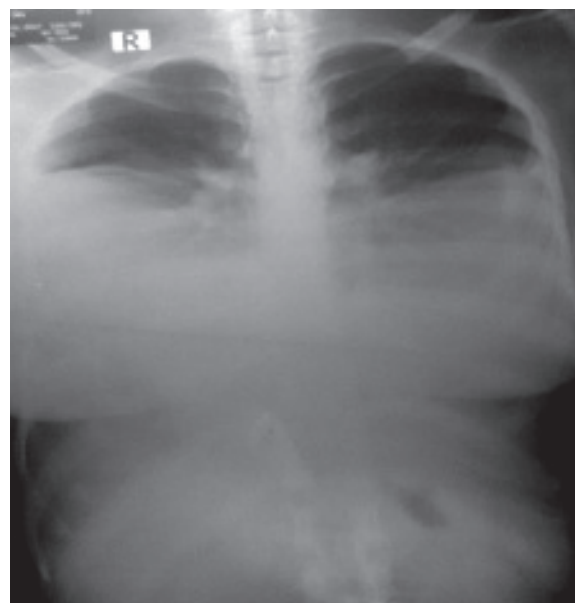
Chest x-ray PA view
